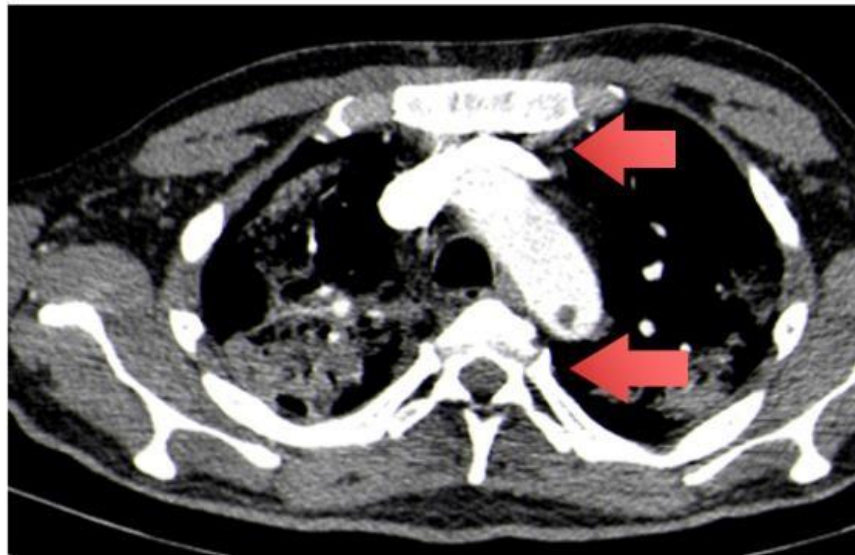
Angio-CT showing thrombotic apposition at the level of aortic isthmus
